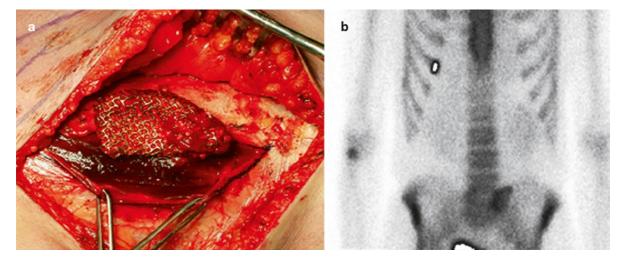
Second and third procedures. (a) The titanium cage filled with beta-tricalcium phosphate and adipose stem cells, before insertion in the prepared rectus abdominis muscle pouch. (b) The bony regenerate in the rectus abdominis muscle. Skeletal scintigraphy was performed to confirm bone activity. (c) The rectus abdominis free-flap raised, muscle pouch and titanium
